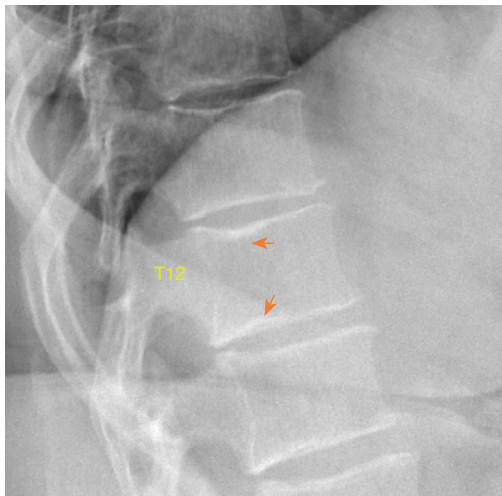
Radiograph shows depression of posterior parts of vertebra T12 upper and lower endplates (arrows) and associated sclerosis. These changes may be a small version of SNd or a small version of cupid bow change. SNd, Schmorl's node of developmental cause.
